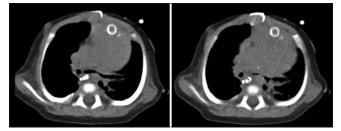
Dynamic computed tomography demonstrating left bronchus collapse upon inspiration (left) and expiration (right) before aortopexy
